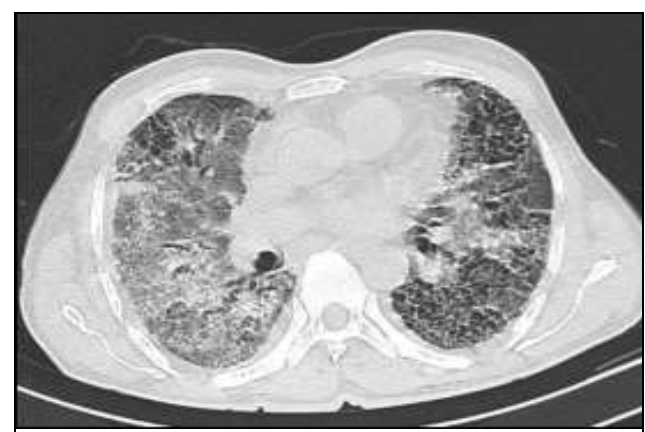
HRCT Thorax in Non-Specific Interstitial Pneumonia (NSIP) Delineating Patchy Ground Glass Opacities with Fibrosis and Honeycombing
